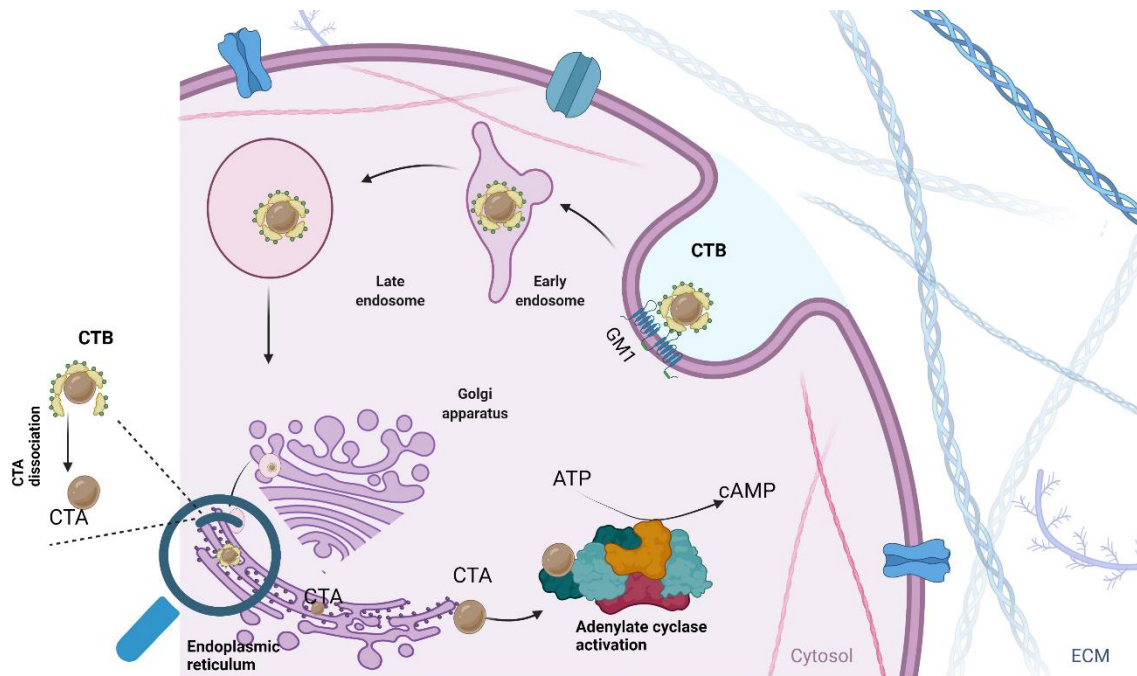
The current paradigm for the entrance and poisoning of CT, CT's binding to the ganglioside GM1 efficiently clusters the lipid on the cell surface, where it may be endocytosed through clathrin-dependent or -independent mechanisms. CT is transported to the endoplasmic reticulum (ER) through a retrograde transport route after endocytosis. CTA dissociates from CTB as it reaches the ER. CTA1 enters the cytoplasm of the cell and activates adenylate cyclase, converting ATP to cyclic AMP.
